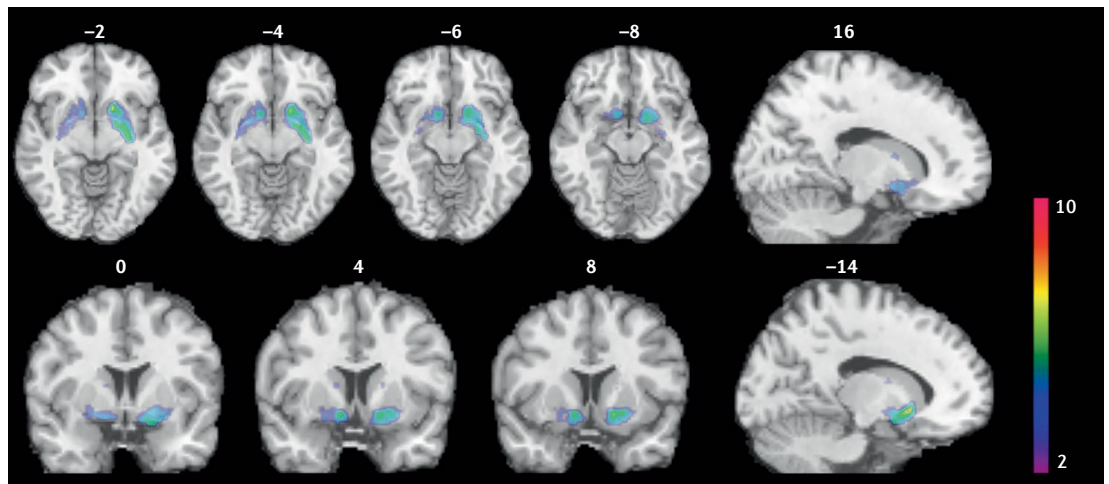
PET imaging shows elevation of dopamine in the human brain after smoking. Smokers received brain PET scans with [^{11}C]PHNO, a dopamine $\text{D}_{2/3}$ PET tracer that has high sensitivity in detecting fluctuations of dopamine. PET scans were performed during abstinence or after smoking a cigarette. Reduced binding potential (BP_{ND}) was observed after smoking, indicating increased dopamine levels in the ventral striatum and in the area that corresponds to the ventral pallidum. The images show clusters with statistically significant decreases of [^{11}C]PHNO BP_{ND} after smoking a cigarette versus abstinence condition. Those clusters have been superimposed on structural T1 MRI images of the brain. Reprinted from REF.⁶⁵, Springer Nature Limited.
